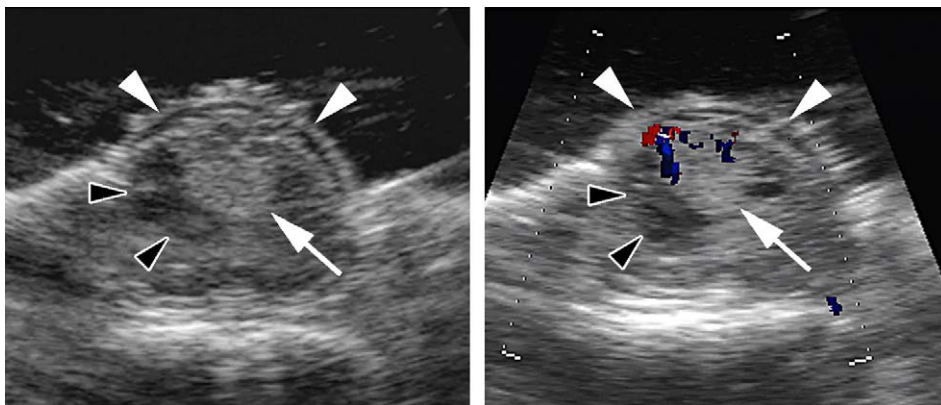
Intraoperative ultrasound is used to determine the precise location of the spinal cord hemangioblastoma with respect to the exposed dura and to confirm the adequacy of exposure of the tumor within the bony opening. (*Left*) Axial intraoperative sonographic imaging clearly demonstrates the dura (*white arrowheads*), the underlying highly echogenic spinal cord hemangioblastoma (*white arrow*), and an associated syrinx (*black arrowheads*). (*Right*) Corresponding Doppler flow analysis of the same hemangioblastoma in the axial plane demonstrates the high-velocity blood (*colored pixels*) flow to and from the tumor. (*From* Lonsler RR, Oldfield EH. Microsurgical resection of spinal cord hemangioblastomas. *Neurosurgery* 2005;57(4):372–6; with permission.)
